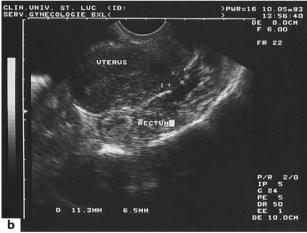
Barium enema: profile radiography offers the best evaluation of infiltration of the anterior rectal wall. (a) Typical 'endometriotic' infiltration of the anterior rectal wall without stenosis; intact mucosa. (b) The same patient, showing evaluation of rectal infiltration by vaginal echography
